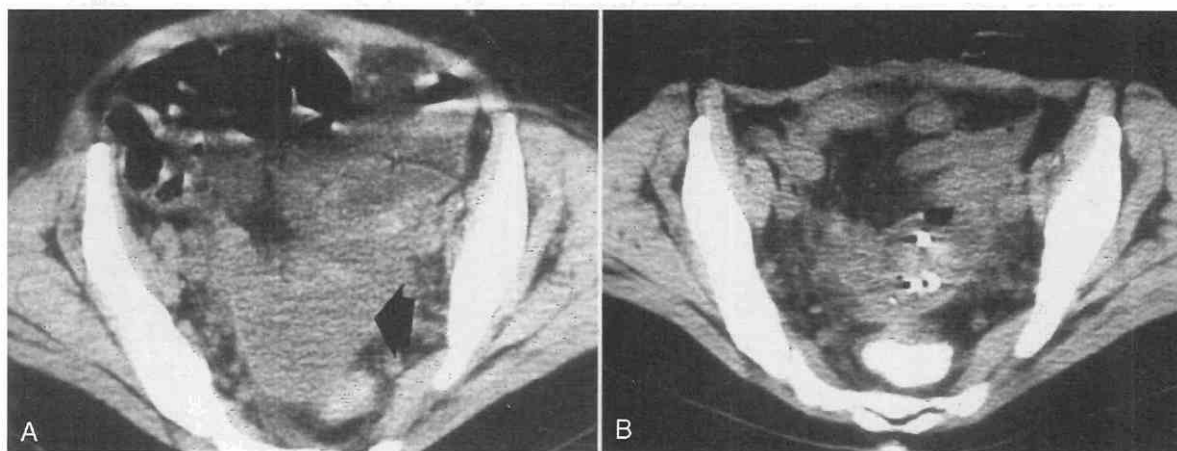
A, CT scan shows large high-density mass (arrow) in the posterior pelvis. The mass proved to be an infected hematoma following hysterectomy. The patient had systemic lupus and was on high doses of systemic steroids. Even with these complicating factors, the patient was cured by percutaneous drainage enhanced by urokinase irrigations. B, Follow-up scan shows reduction in size of cavity with a high-density catheter in place. There was ultimately total resolution without surgical treatment.
